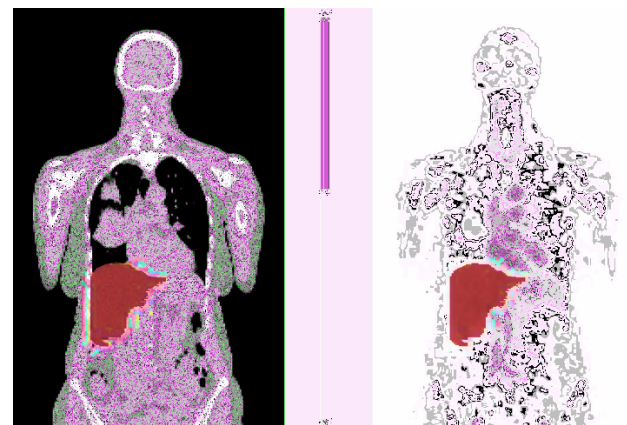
Low-dose CT and PET example patient 4 images in coronal view. The manually adjusted AI-based volume segmentation represented in red, corresponds to the liver.
